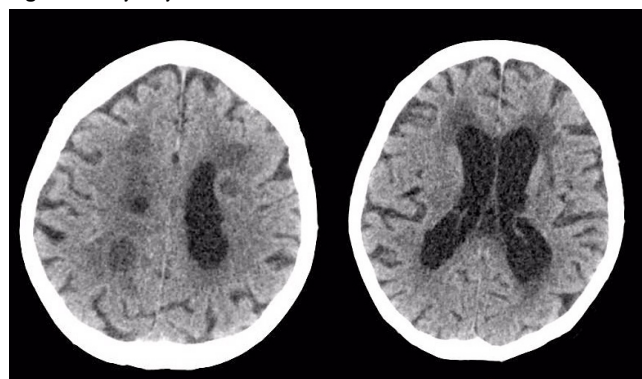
Non enhanced CT scan revealing multiple intercerebral masses
